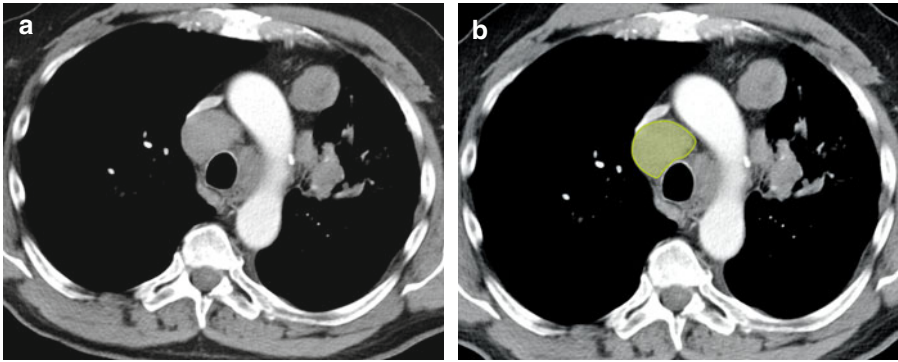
(a, b) Axial contrast-enhanced CT image through the upper thorax shows an enlarged right-sided lower pretracheal lymph node (*green*)
